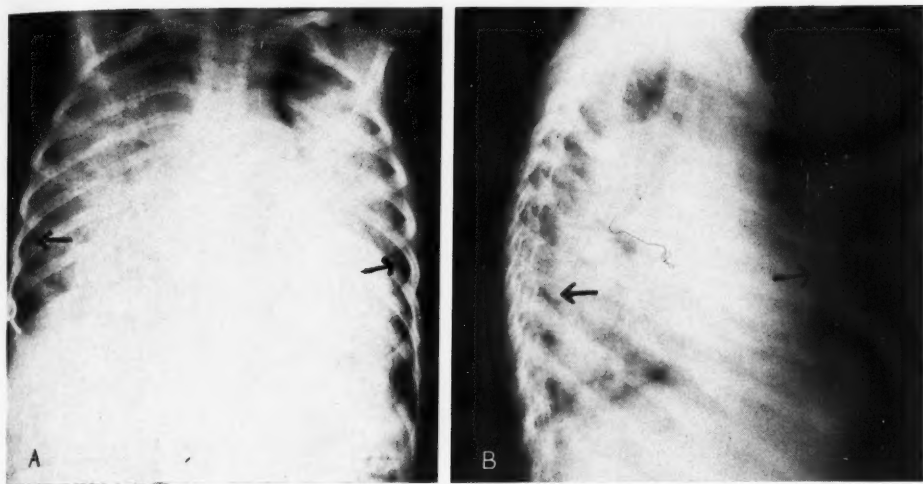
Case 1: A. Postero-anterior roentgenogram. Typical pulmonary edema from cardiac failure. Note the bilateral, symmetrical, butterfly-shaped densities with the relatively clear periphery (arrows). While not completely homogeneous, the shadows show only slight mottling and are so dense that it is difficult to distinguish the cardiac shadow from them. Confirmed at necropsy.
